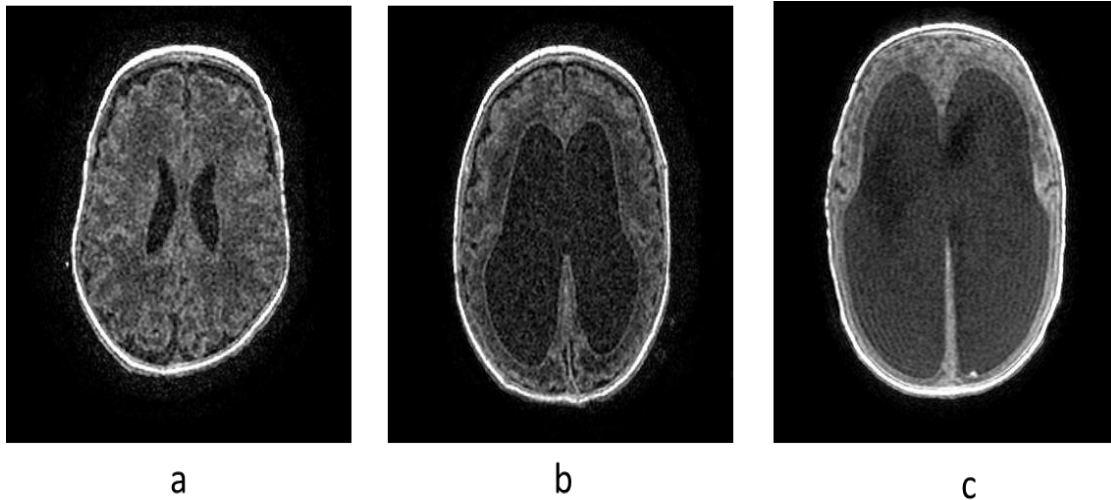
MRI of the brain of a) 26 weeks neonates with grade I IVH b) 27 weeks neonate with grade III IVH with hydrocephalus and c) 25 weeks neonate with grade III IVH with severe hydrocephalus.
